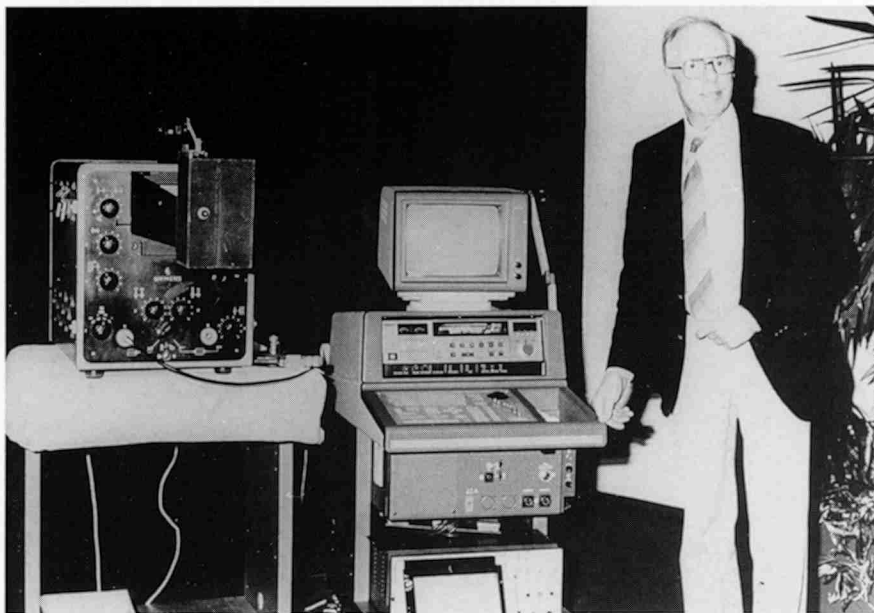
The late Professor Hertz pictured here with, on the left, the Siemens Ultraschall-Impulsgerat which he modified for cardiology. Inge Edler and Hellmuth Hertz used this apparatus to produce the first echocardiograms in 1953. This picture taken in 1982 also shows in the centre a Siemens Sonoline CD echocardiography scanner.
